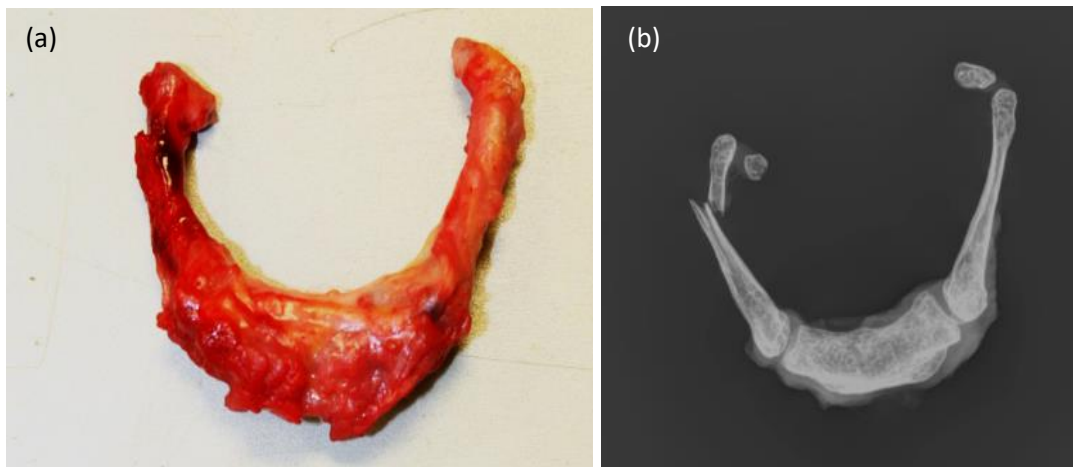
(a) Autopsy & (b) Radiograph demonstrating clear delineation of the right hyoid cornu fracture.
